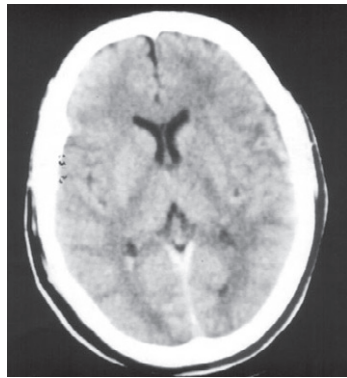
CT showing subarachnoid haemorrhage in basal cisterns with DAI with temporal pole contusion.
